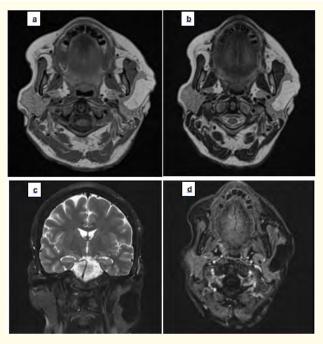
Parotid MRI: Left parotid lesion, at the expense of its superficial portion, oval in shape, well limited, with regular contours, homogeneous, hyper signal in T1 and T2 (a, b), suppressed after fat saturation (c), not enhanced after gadolinium injection (d), measuring 40x20x35 mm.
